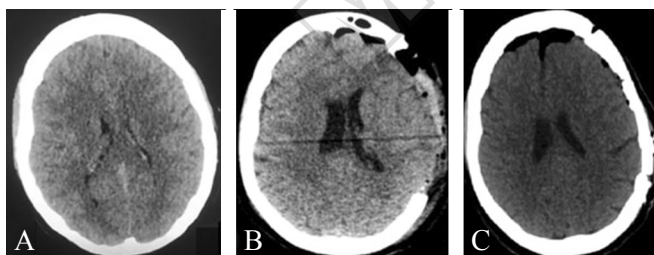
CT of patient #1. A) Before craniectomy brain CT; B) postcraniectomy brain CT; C) postcranioplasty brain CT.
